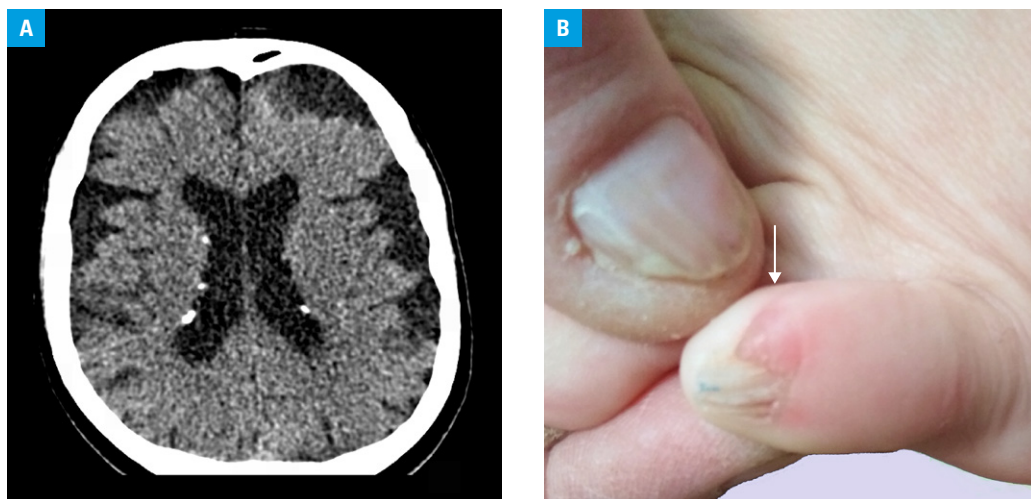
Imaging of an adult woman with tuberous sclerosis: A – computed tomography of the head showing calcified subependymal nodules; B – unguinal fibromas around the toenail (arrow)
